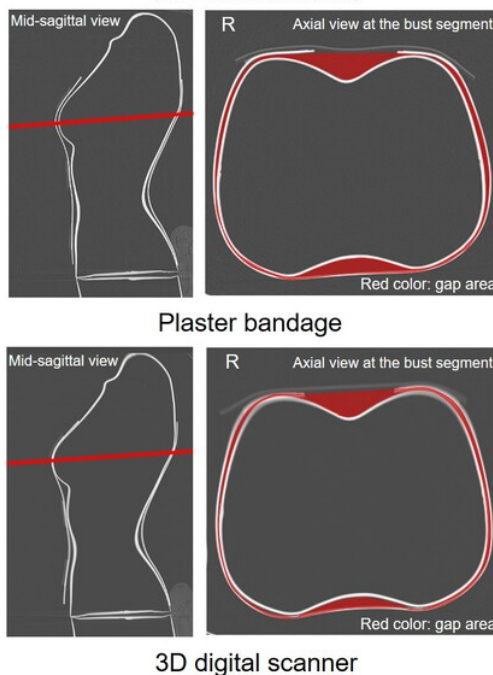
Findings of axial CT analysis at the bust segment.
